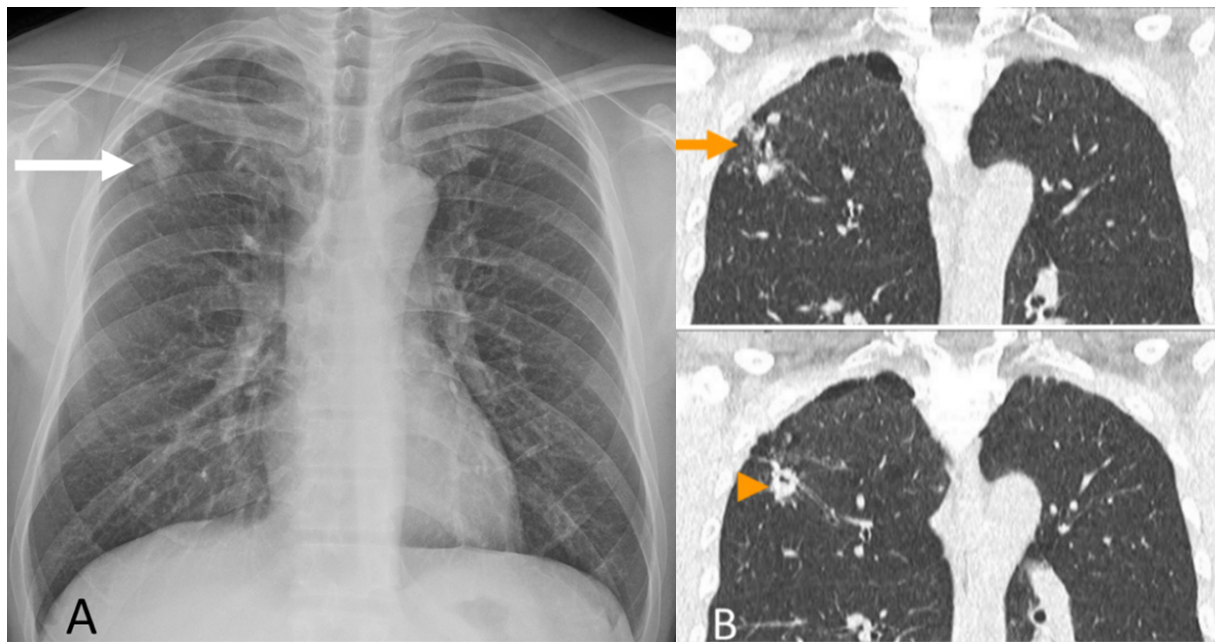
Detection of subclinical tuberculosis on ultra-low dose CT: 51-year-old male patient diagnosed with rectal cancer and underwent ultra-low dose CT for metastasis work up. A chest radiograph shows ill-defined nodular opacities in the right upper lung zone (arrow, A). An ultra-low dose CT performed on the same day (B) shows small nodules in the right upper lobe (arrow) and a cavitary nodule (arrowhead). This case is subclinical tuberculosis, for which ultra-low dose CT is very useful for diagnosing early tuberculosis.*
